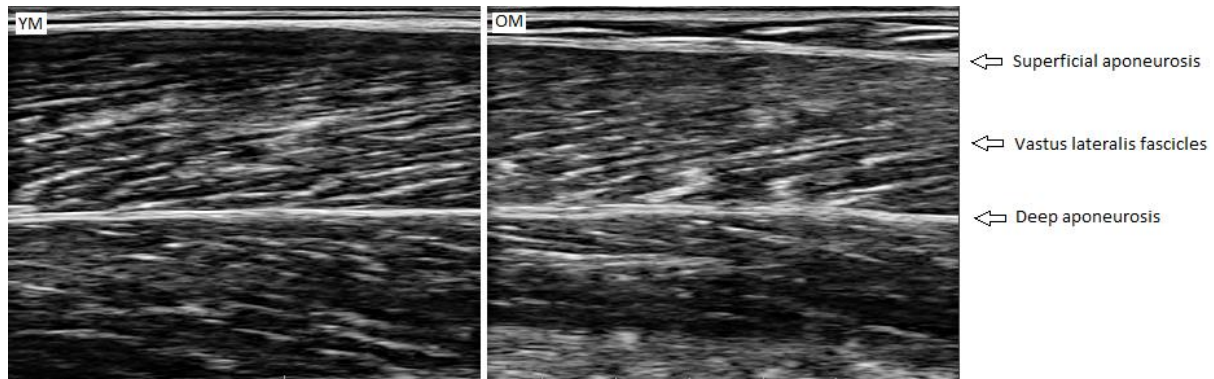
Example of sagittal plane sonographs in a young (YM) and older (OM) man.
